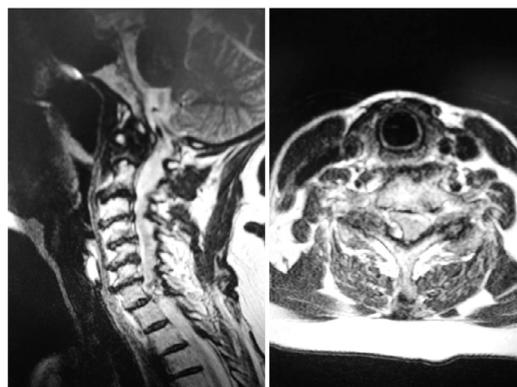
Sagittal and axial T2 MRI.
